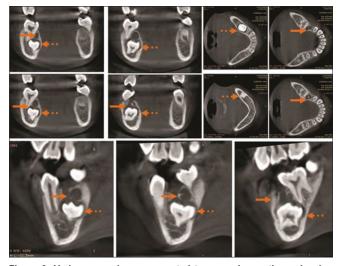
Various cone-beam computed tomography sections showing severely impacted tooth 85 (dotted arrows) and formation and presence of tooth germ 45 (arrows)
